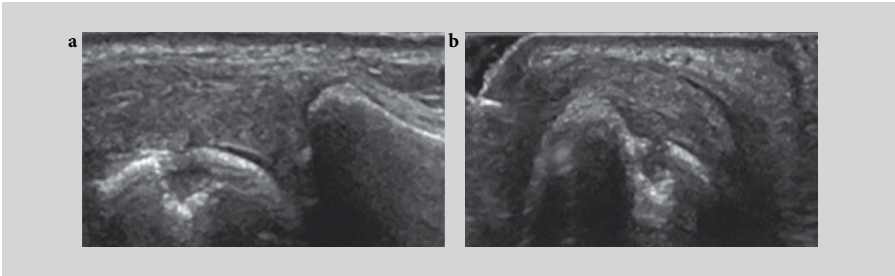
Ultrasound detected erosion of a metacarpal head in a dorsal (a) longitudinal and (b) transverse scan.
